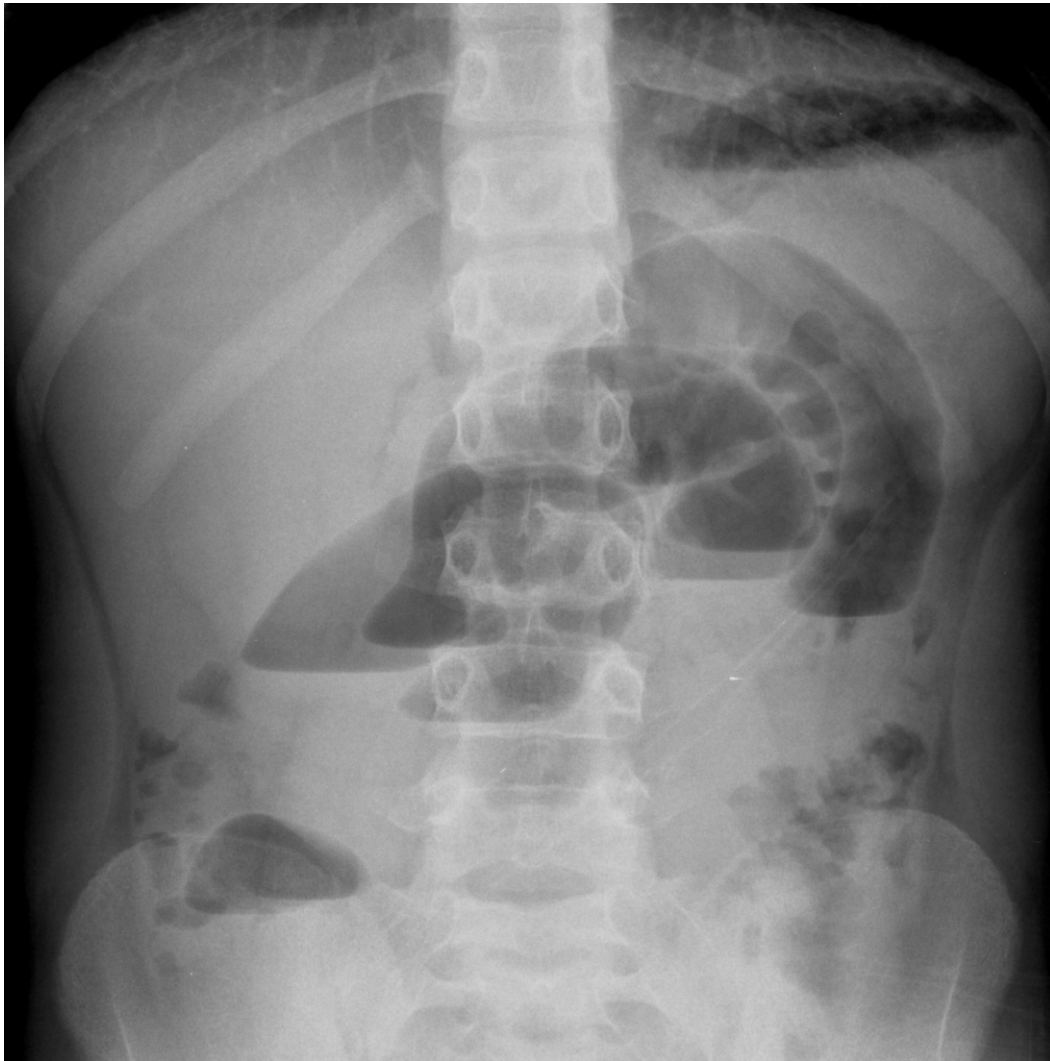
Abdominal X-Ray
